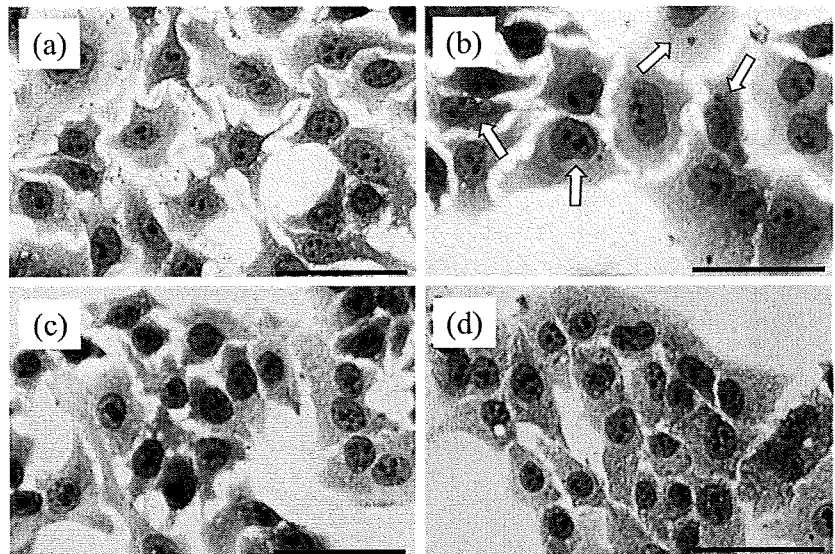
Representative figures of cells with micronuclei. (a) HepG2 cells without irradiation. (b) HepG2 cells after exposure to 5×2 Gy of X-rays. Cells with micronuclei (white arrows) are obviously observed. (c) HepG2-8960-R cells without irradiation. (d) HepG2-8960-R cells after exposure to 5×2 Gy of X-rays. Scale-bar: $50 \mu\text{m}$.
